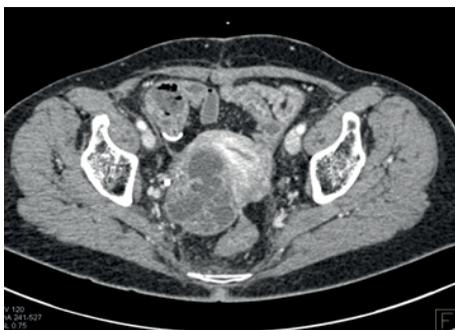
CT abdomen and pelvis showing right sided ovarian mass
